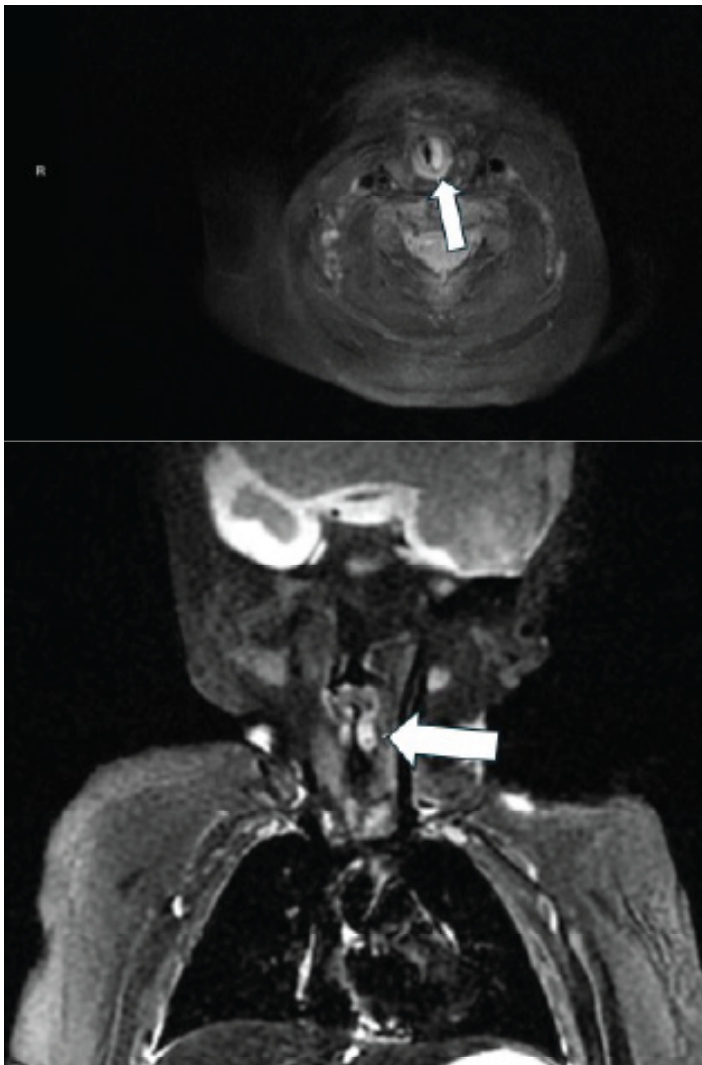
Neck and chest magnetic resonance imaging showing an enhancing lesion in the left subglottic larynx consistent with subglottic hemangioma, axial view above and coronal view below (arrows).
